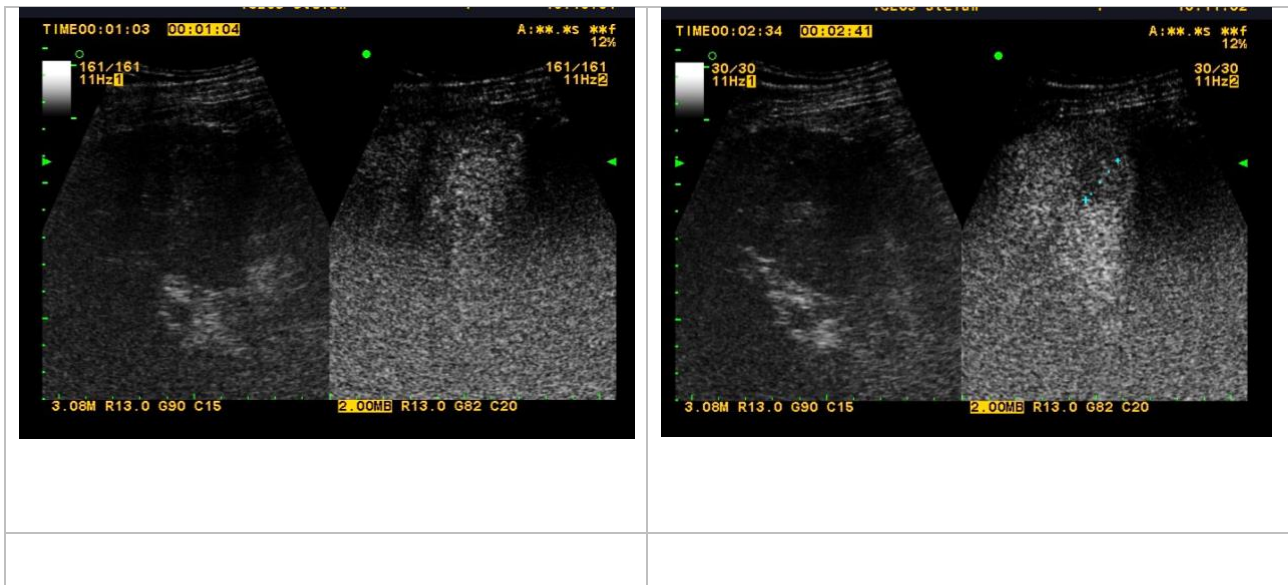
Ultrasonography including contrast enhancement (arterial, portal and late venous phase after SonoVue application) in a patient with cirrhosis and focal lesion.
